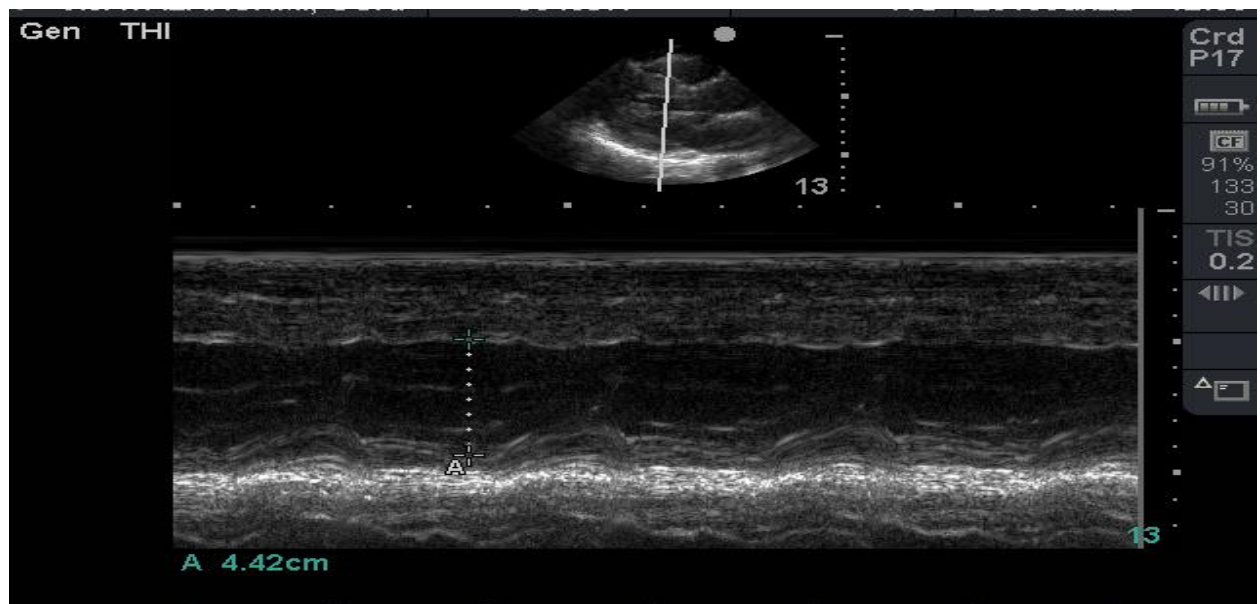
Diastolic measurement in parasternal long axis (PLAX) view
